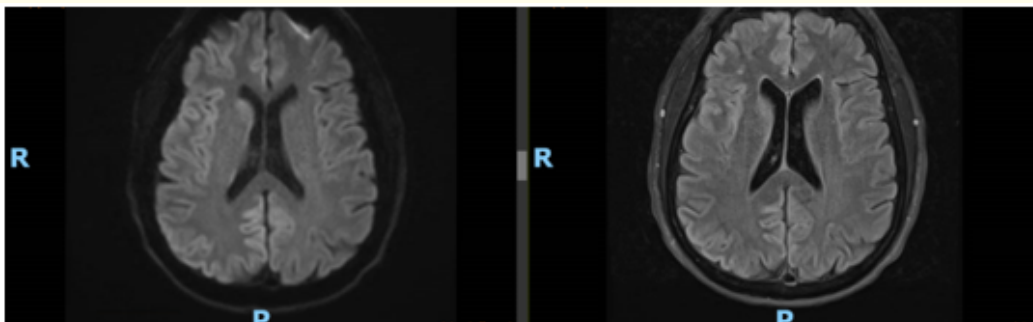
Left - MR Brain with and without IV contrast. Series Desc: AX T2 FLAIR.
